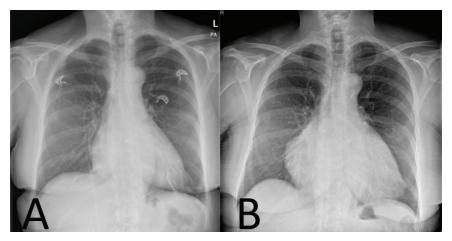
(A) An older X-ray showing the normal heart figure of this patient. (B) The X-ray upon admission showing an increased heart figure and the absence of pulmonary TB.
